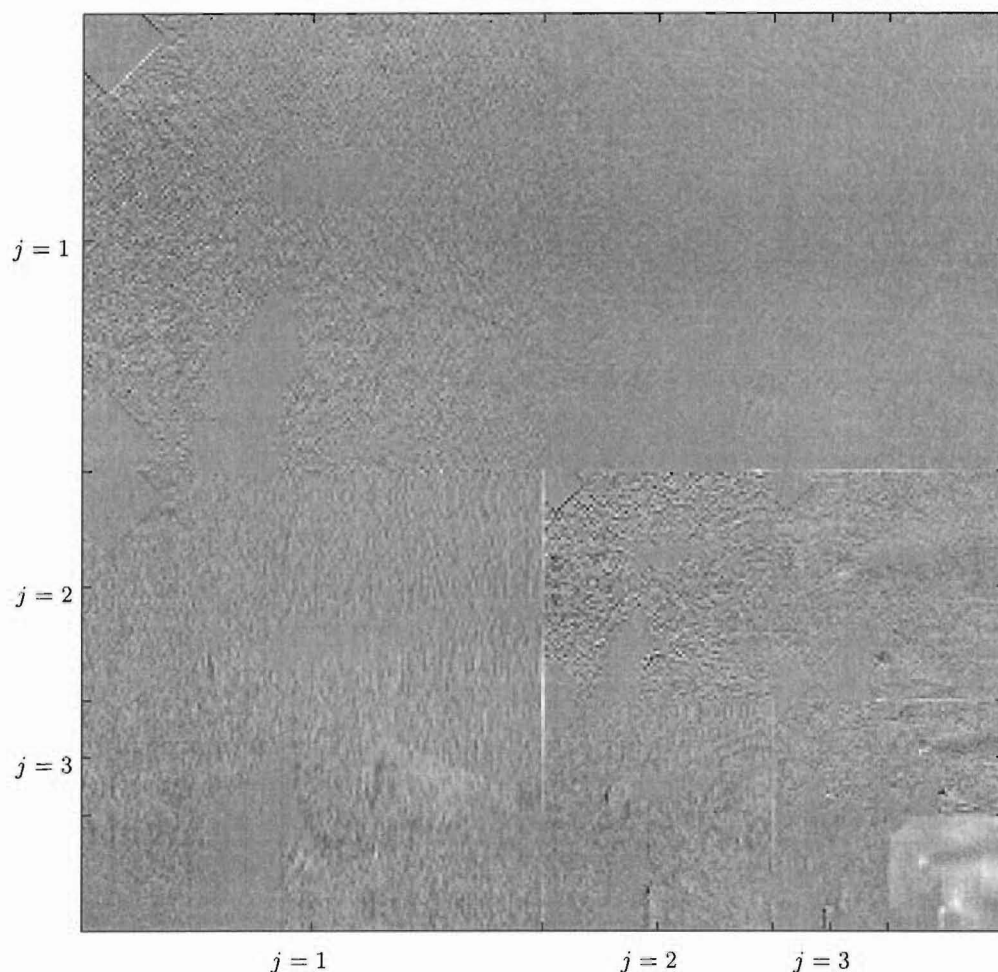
Separable wavelet transform of the ultrasound image.
